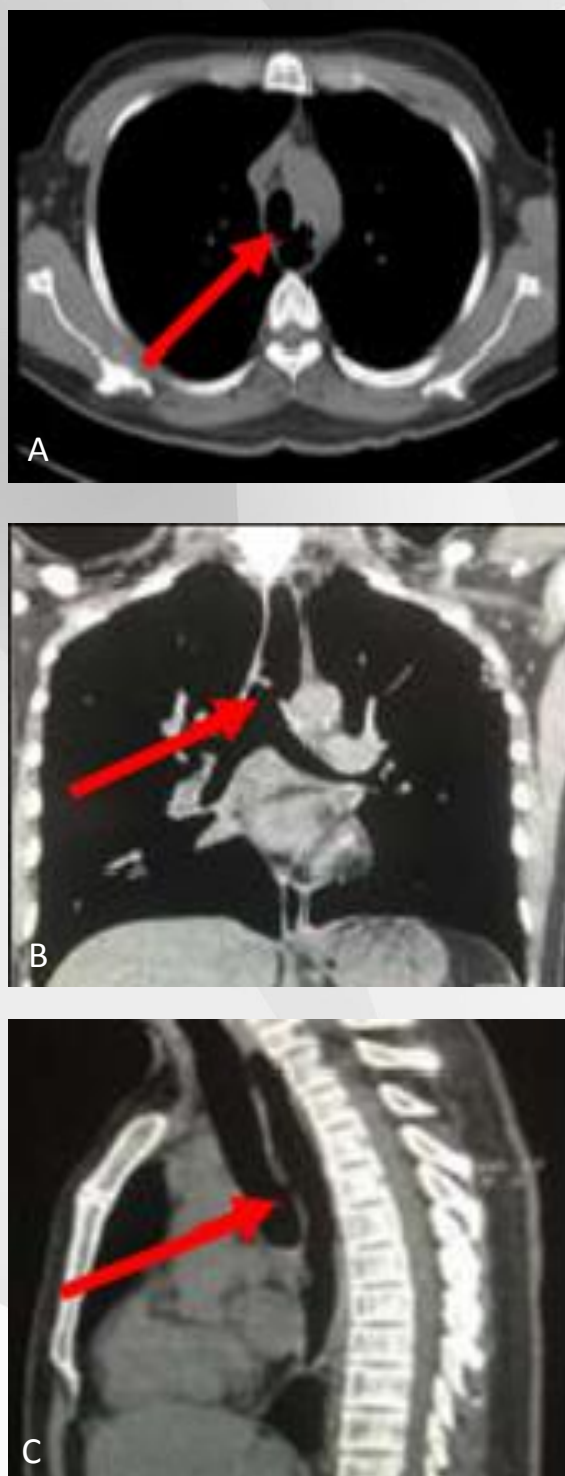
Case 1. Chest CT scan axial view (A), coronal view (B) and sagittal view (C) showing esophageal erosions and ulcerations (arrows).
